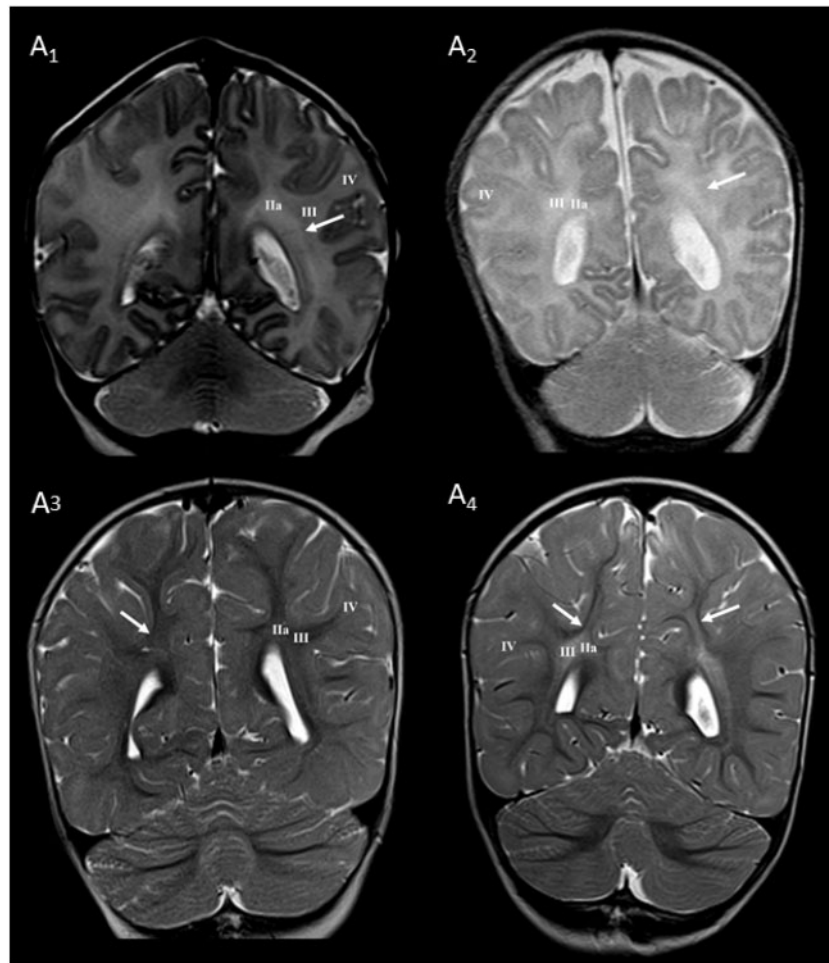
Longitudinal MRI follow-up of the centrum semiovale perinatal lesion on coronal T2 images. Normal findings of the centrum semiovale at term age (A1) with a visible border between the parietal crossroad and centrum semiovale (arrow in A1). Normal findings at the age of 13 months with a barely visible border between U-fibers and the centrum semiovale (arrow in A3). Term born child with perinatal asphyxia and diffuse hyperintensity of white matter with a diminished border between parietal crossroad and centrum semiovale at term equivalent age (arrow in A2) but with enhanced visibility of a border between U-fibers and the hyper-intensive centrum semiovale at the age of 13 months (arrows in A4). Numbers I–IV represent segments of white matter as previously described. Reprinted from Kostović et al (21) with permission.
